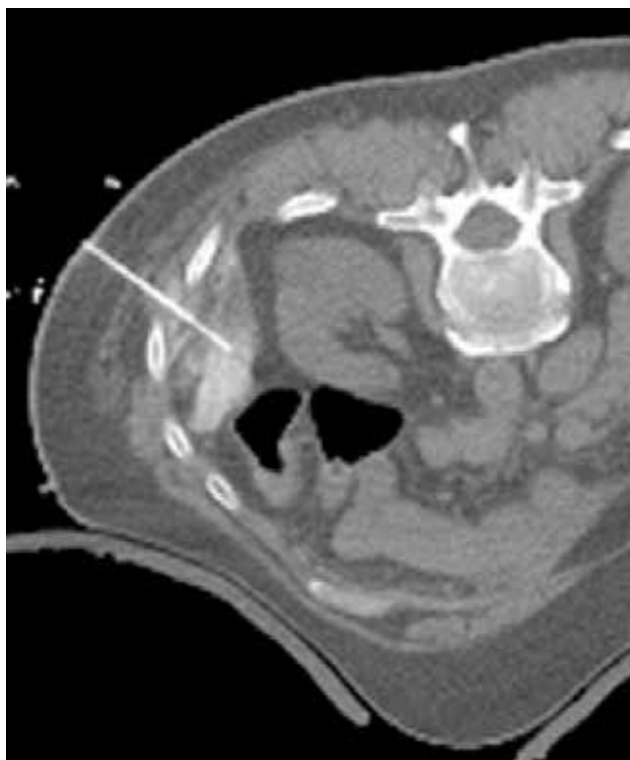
CT Fluoroscropy shows placement of a 20G Chiba needle for hydro-displacement of the splenic flexure of colon with instillation of dilute iodinated contrast into the space between the tumor and colonic wall. This maneuver prevents cryoablation injury of the bowel.
